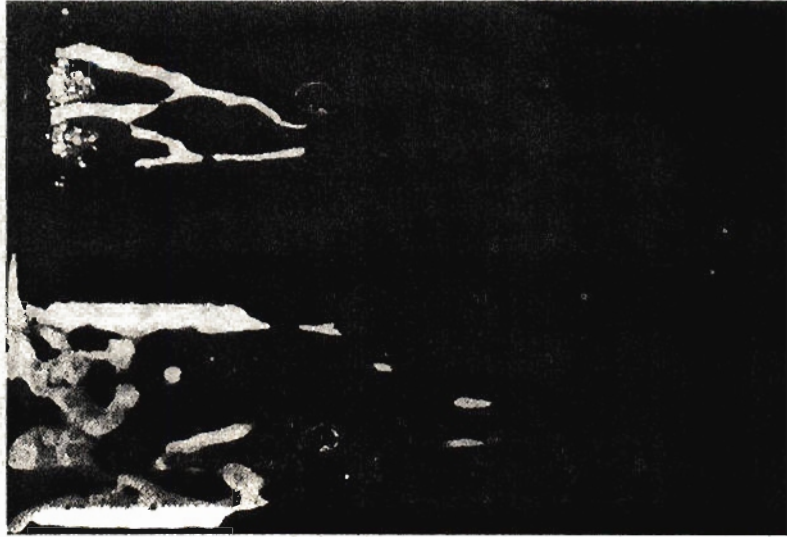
Radiographic comparisons of bone ingrowth into rough-surfaced CP titanium and plasma-HA coated CP-titanium-lined ingrowth channels at 6 weeks. (a) Faxitron high-resolution x-ray of an intact chamber with surrounding bone, showing increased bone ingrowth into the plasma-HA-lined channels (2nd, 4th, 6th, 8th, and bottom channels). (b) Comparison microradiographs demonstrating increased bone ingrowth in the plasma-HA-lined channel (bottom) vs. CP titanium (above) (original magnification $\times 33$).
